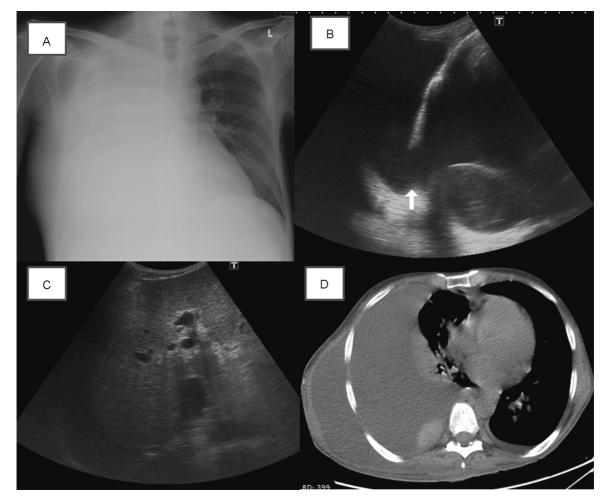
(A) Chest X-ray showed gross right pleural effusion with soft tissue opacity along the right lateral chest wall. Chest ultrasound revealed communication between the pleural cavity and chest wall characteristic of pleurosubcutaneous fistula (B) and underlying cirrhotic liver (C). Axial image from the noncontrast chest computed tomography also demonstrated gross right pleural effusion, and fluid collection was seen beyond the rib margin deep to right lateral chest wall muscle (D).
